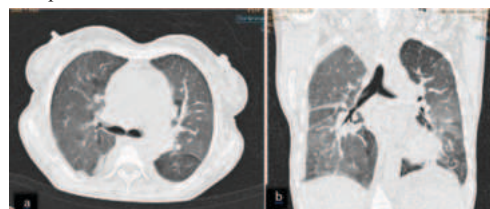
Axial (a) and coronal (b) HRCT section of lung window showing reticular opacities, with diffuse ground glass opacities. Findings are in favour of non-specific interstitial pneumonia.
